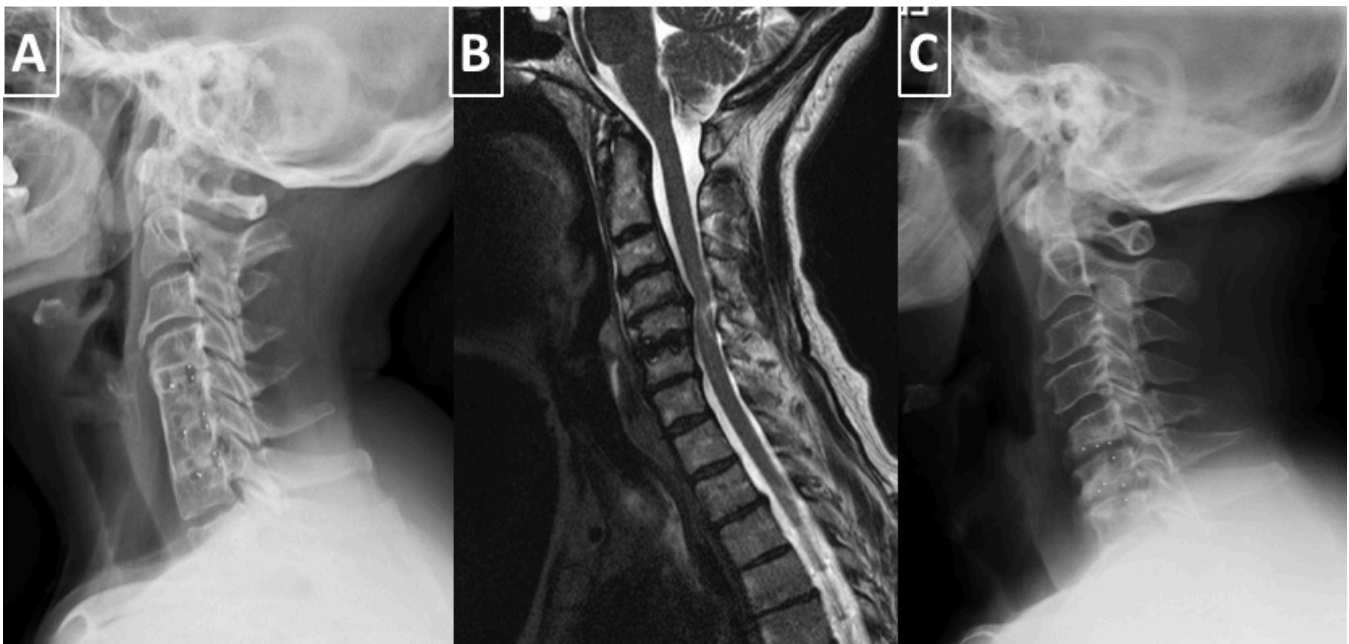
(A) Lateral x-ray image of a patient treated with 3-level stand-alone anterior cervical discectomy and fusion (ACDF) technique who developed bony fusion between intervened cervical levels. (B) Sagittal plane T2-weighted magnetic resonance image of a patient treated with single-level stand-alone ACDF technique who developed adjacent segment disease. (C) Lateral x-ray image of a patient treated with 2-level stand-alone ACDF technique who developed subsidence of intervened cervical levels.
